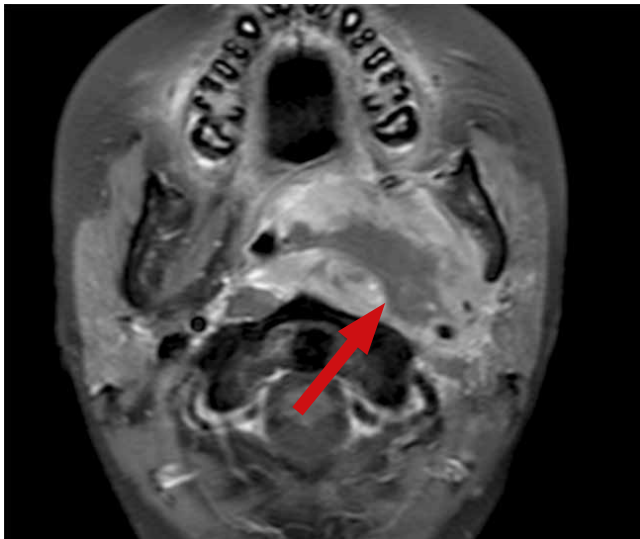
MRI in T1-VI with contrast enhancement and fat suppression in axial projection and T2-VI with fat suppression in sagittal projection. Tumor mass of the lateropharyngeal space on the left with ingomogenous intensive contrast accumulation; left tonsilla involvement, nasal pharynx and pharynx invasion.
